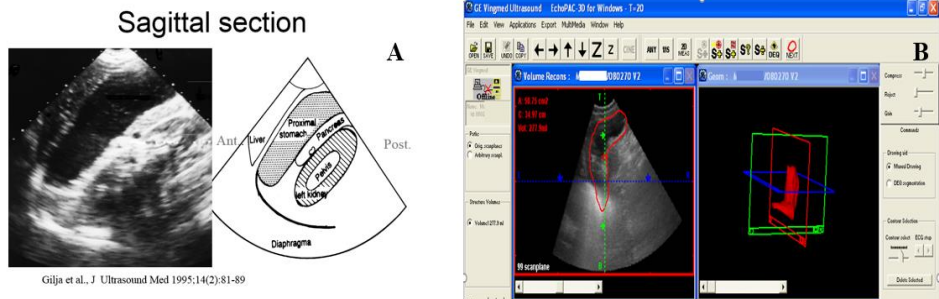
Assessment of the accommodation of the proximal stomach by using 2 D (A) and 3D (B) ultrasound.
